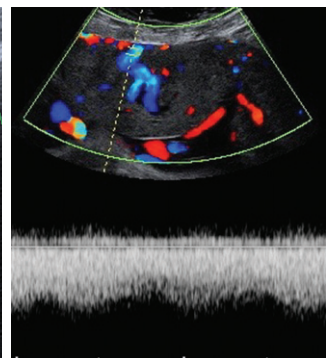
Placental lacunae feeder vessels on color Doppler imaging.
